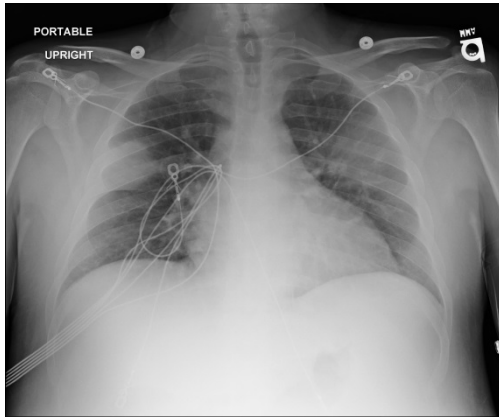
Chest radiograph demonstrated bilateral lung masses.
